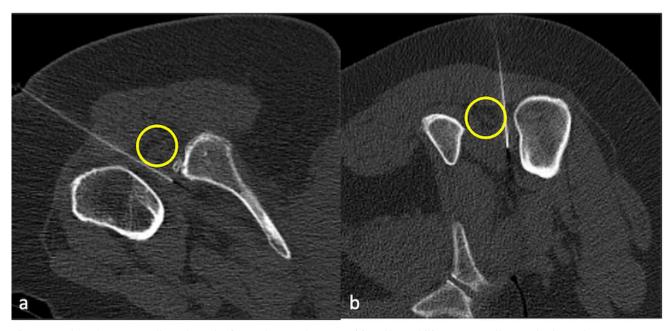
Axial CT showing needle in the ischiofemoral interval in prone (a) and lateral (b) position. Yellow circle shows the sciatic nerve.
